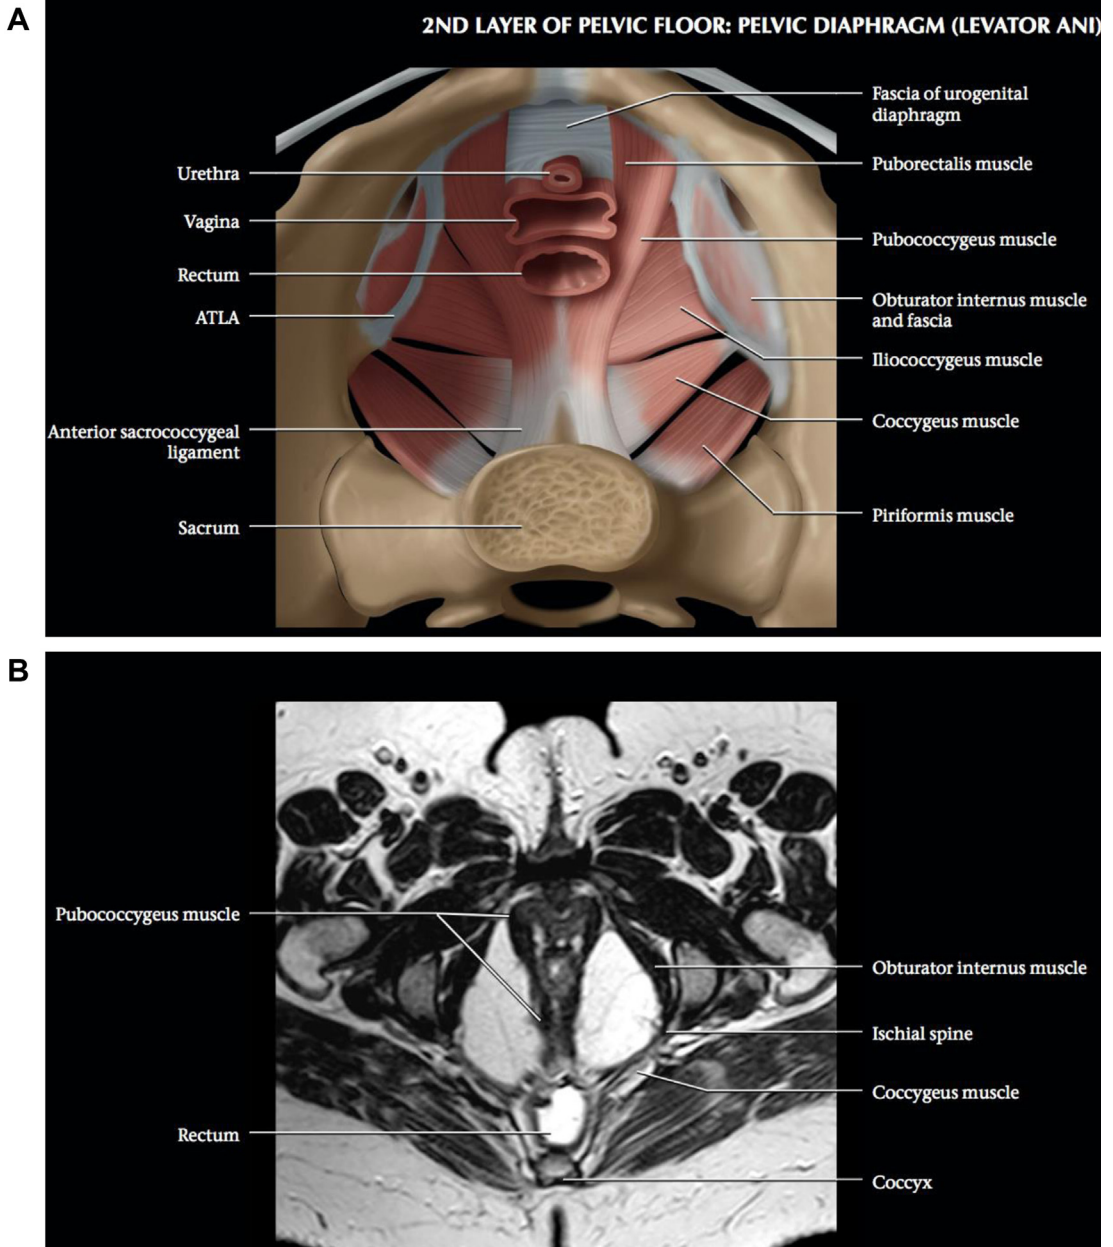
(A) Superior view of the pelvic floor. The puborectalis, pubococcygeus, and iliococcygeus muscles form the levator ani. The obturator internus is covered by a fascial layer, which forms a thick band, the ATLA. This is a crucial area of attachment for the levator ani. The levator ani muscle with the coccygeal muscles forms the pelvic diaphragm (floor). The piriformis muscle contributes to the posterior wall. (B) Axial oblique T2WI MR image shows the pelvic floor and parts of the levator ani. The pubococcygeus muscle passes posteriorly. It has a bony attachment that is different from the puborectalis, which forms a sling around the ano-rectal junction with no bony attachment. (From [El Sayed RF . Overview of the Pelvic Floor. In: Shaaban AM, Editor. Diagnostic Imaging: Gynecology 2nd Edition. Philadelphia: Elsevier-Amirsys; 2015. 8/2 -8/28 ; with permission.]
